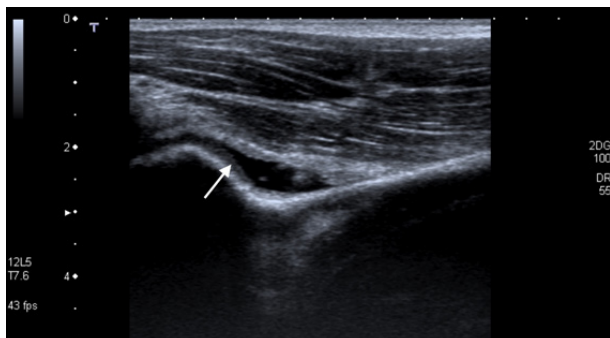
Ultrasound of the elbow depicting synovitis (arrow) with mild joint effusion.
